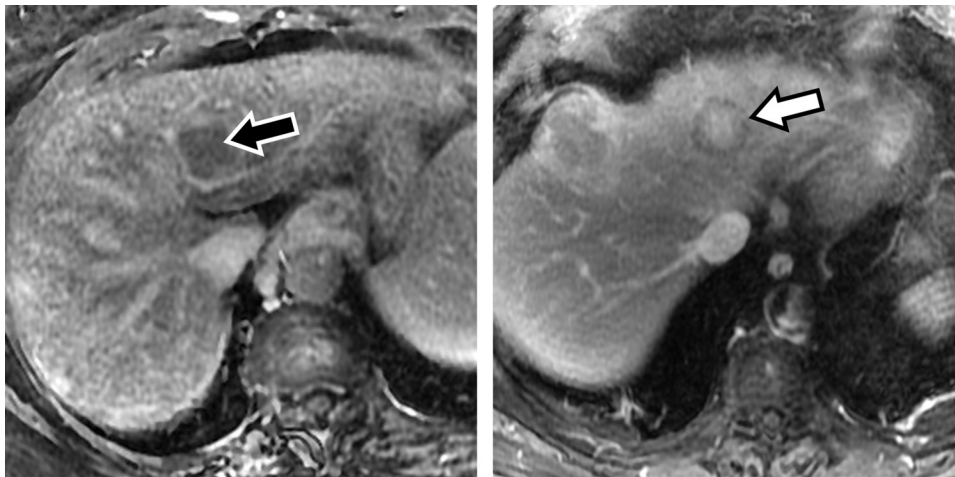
Washout appearance in a 70-year-old woman with a lesion categorized as LR-5 (definitely HCC) (a) and a 79-year-old man with a lesion categorized as LR-M (probably or definitely malignant) (b). Axial T1-weighted delayed phase MR images show a nonperipheral (a) versus peripheral (b) washout appearance (arrow).
